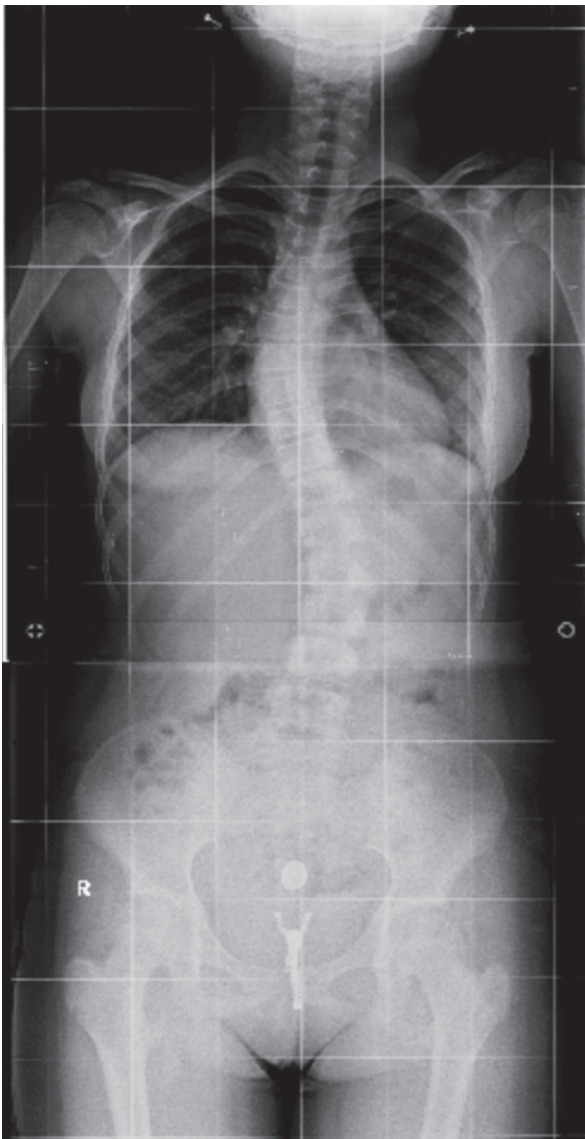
A) Standing anteroposterior radiograph of patient before commencement of treatment with Gensingen brace
